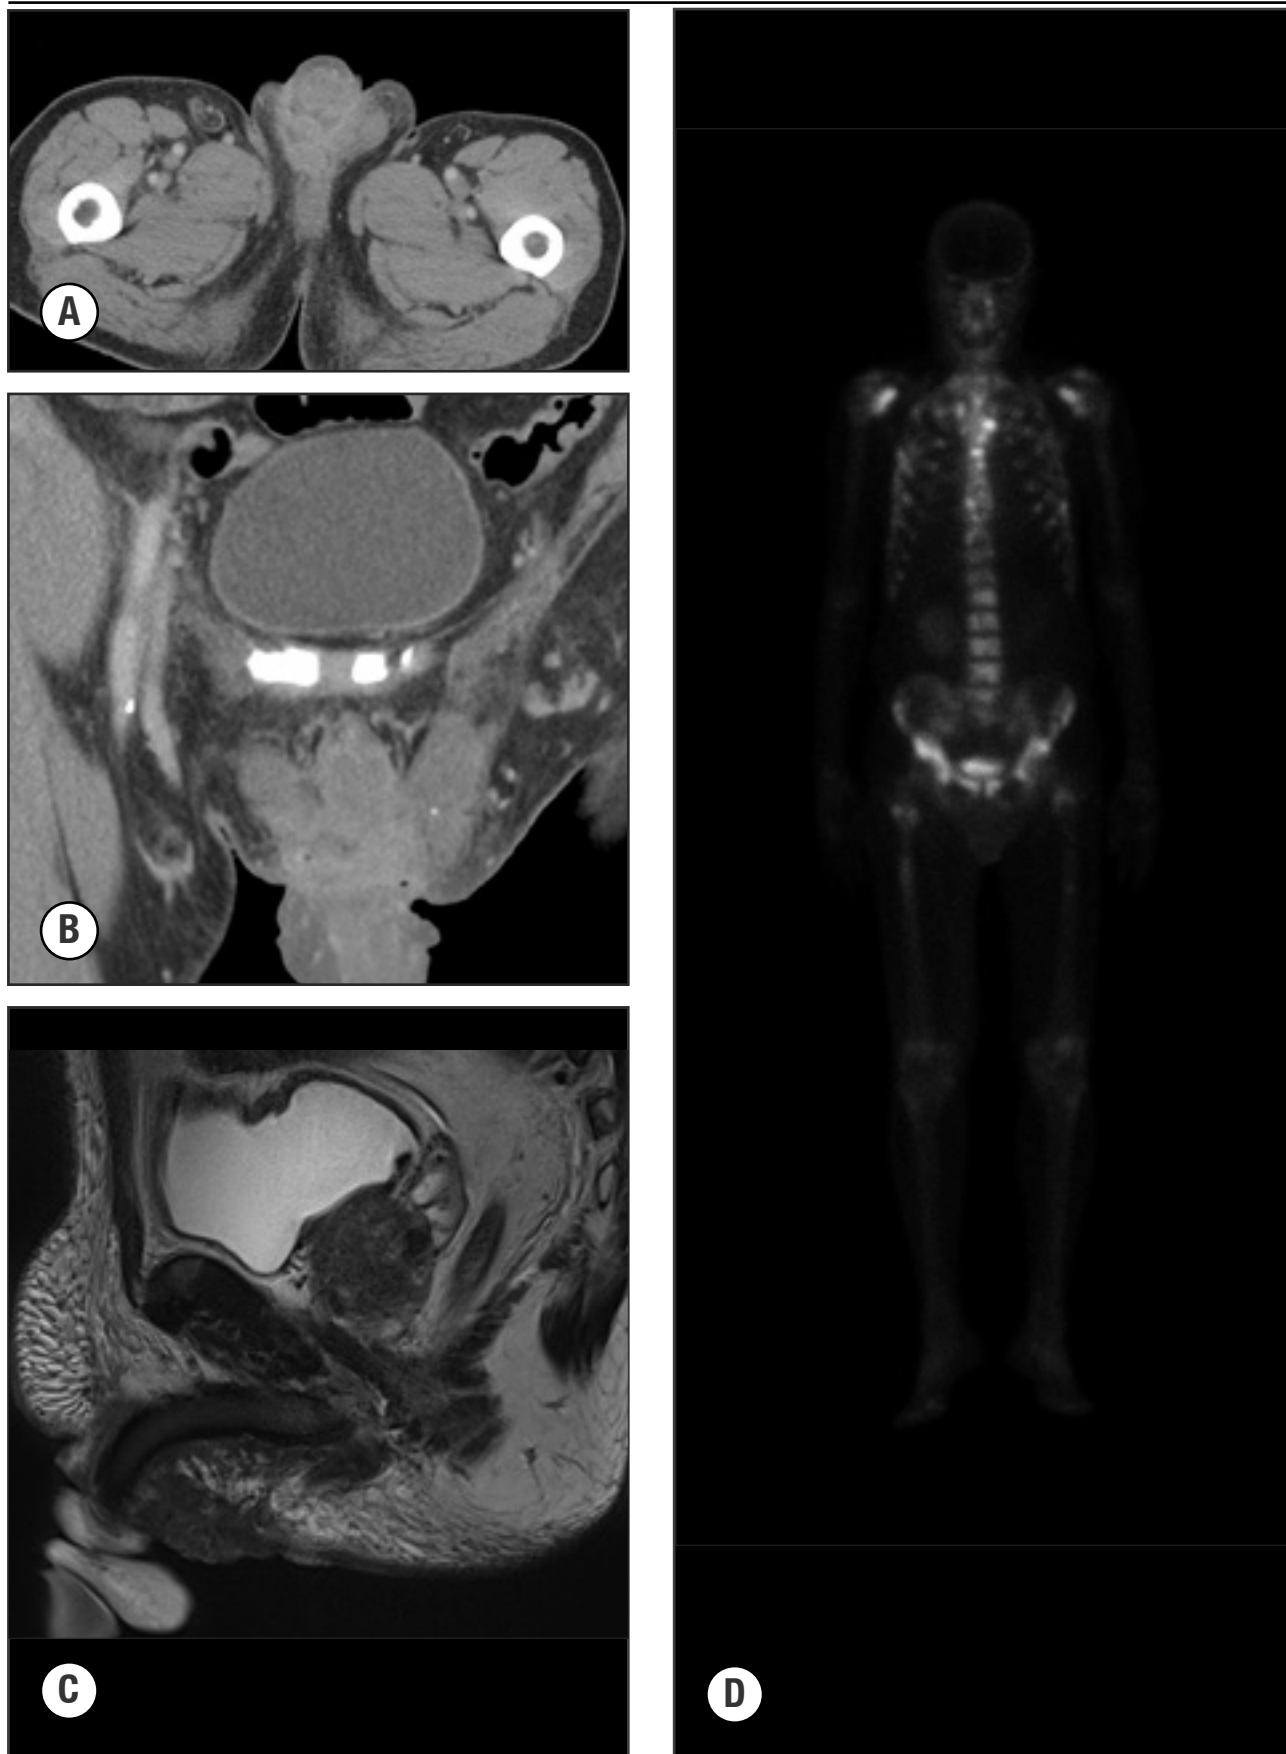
Initial imaging results of the metastatic lesion. CT contrast-enhanced axial (4A) and coronal (4B) images showed an ill-defined soft tissue mass at the base of the penis extending to the perineum. MRI T2-weighted sagittal images (4C) showed an ulcerated lobulated mass at the perineum posterior to the root of the penis. No primary prostatic malignancy was visualized. Bone scan (4D) showed extensive metastases in the axial and proximal appendicular skeleton.
